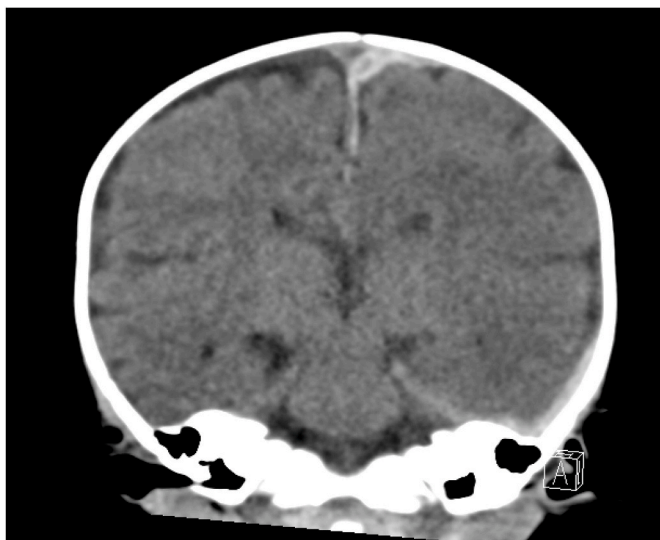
Coronal view of head CT on day of admission.
